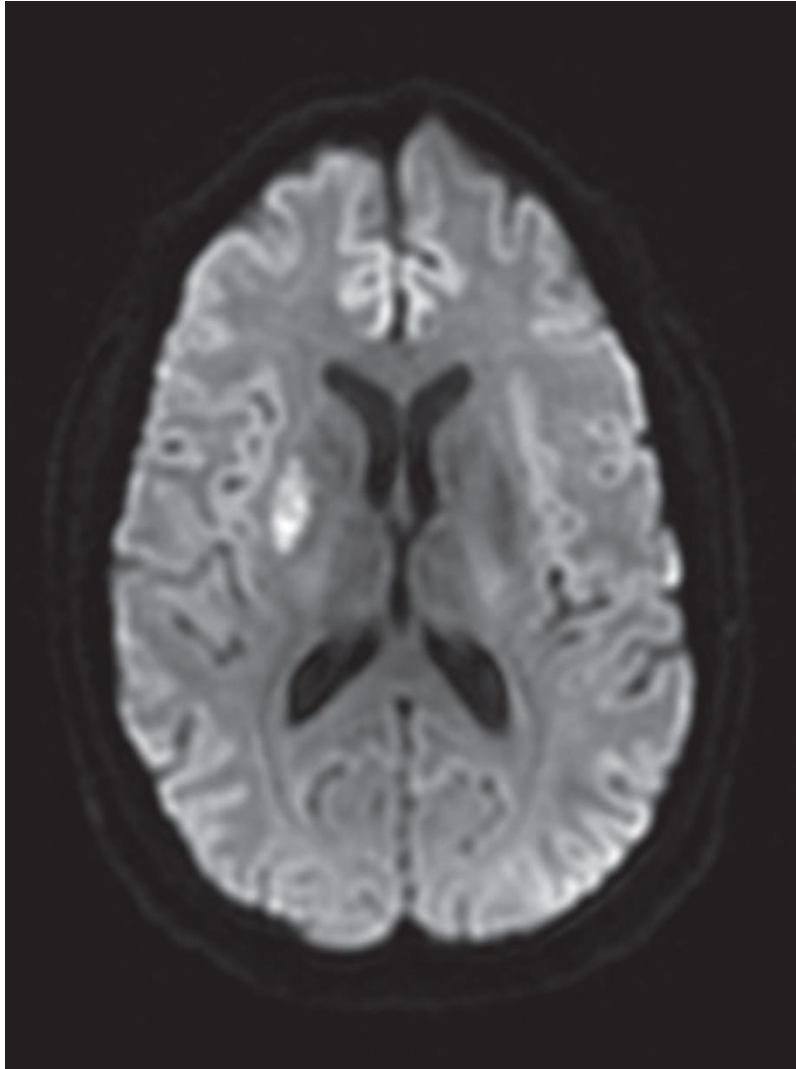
MRI Showing an Acute Ischemic Stroke in the Right Lentiform Nucleus
